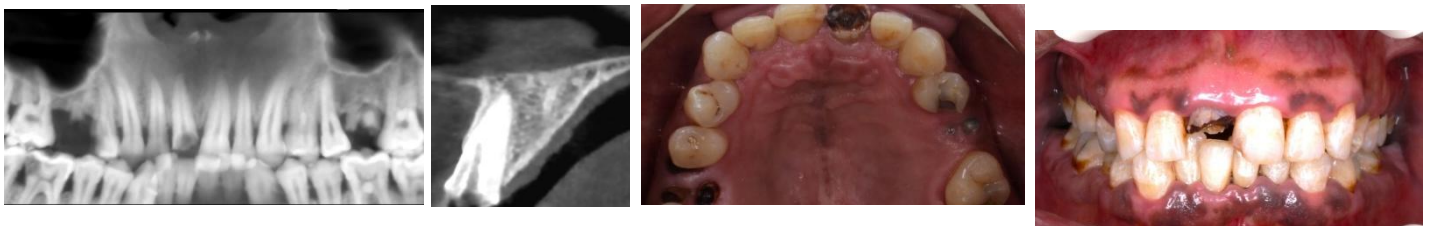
preoperative radiograph and photographs
